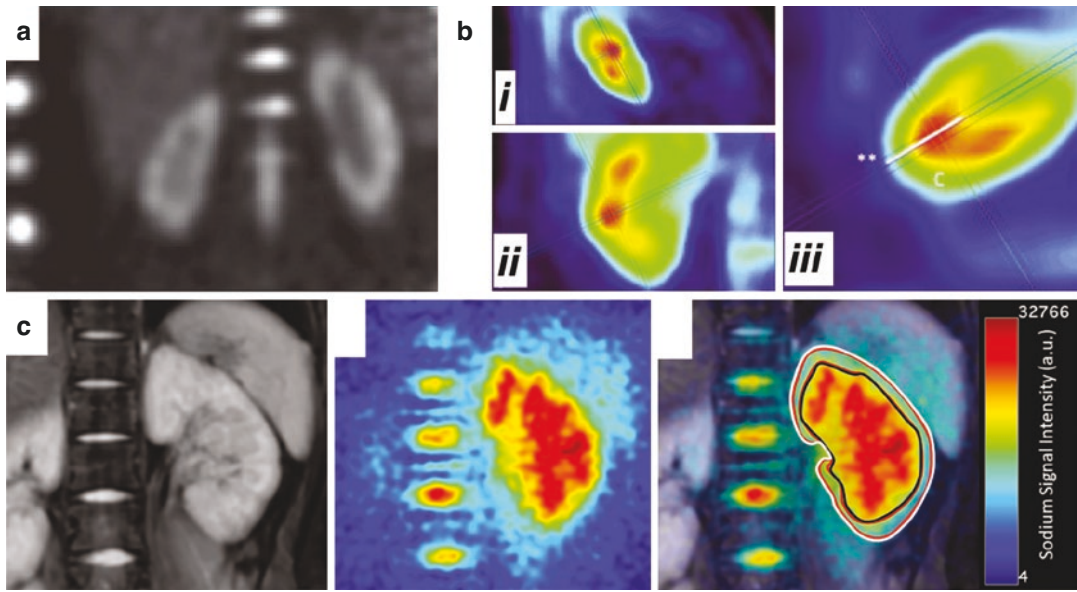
(a) Sodium-weighted 3-T MRI with three sodium standards in the field of view (top to bottom: 0.9%NaCl in 2% agarose, 0.6%NaCl in 2% agarose, and 0.9%NaCl solution). (b) Selection of custom-angled orthogonal image reconstruction planes displayed for (i) sagittal, (ii) coronal, and (iii) axial slices, where the coronal axis aligns with the long axis of the kidney. The sodium corticomedullary gradient profile is measured
